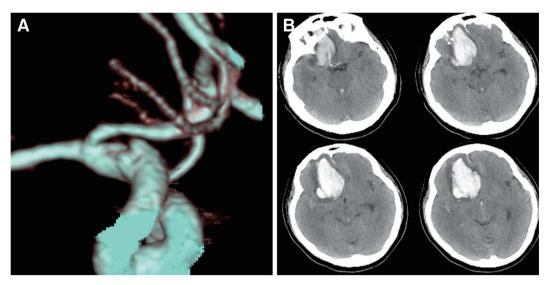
Case 6. A 51-year-old female. She was transported to our hospital owing to headache, nausea, and consciousness disturbance. The Hunt and Kosnic grading system showed grade 5. Consciousness disturbance improved after admission; we planned to perform SAC during the subacute phase. (A) 3D CTA revealed BBA on the right ICA C2 portion. The neck was 3.3 mm, and the height was 1.5 mm. (B) Sudden deterioration of consciousness and bilateral dilation of the pupils occurred on day 14. CT revealed rebleeding. She died 5 days after rebleeding. BBA: blood blister-like aneurysm; ICA: internal carotid artery; SAC: stent-assisted coiling
